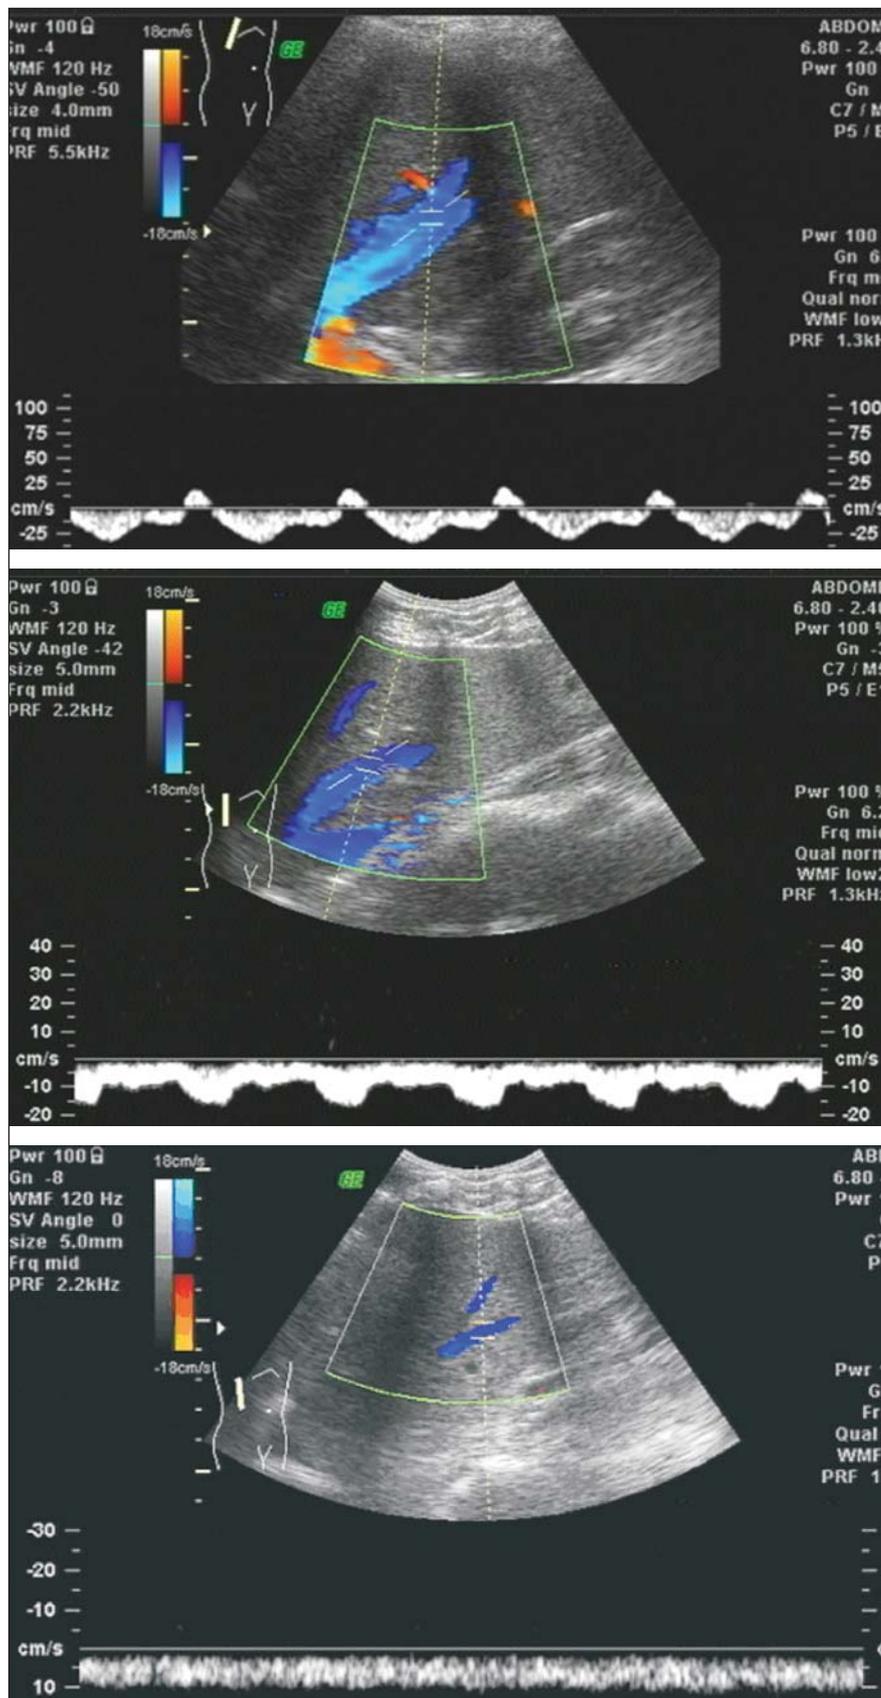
Hepatic vein flow pattern at Doppler. On the upper image, triphasic pattern; on the central image, biphasic pattern; on the lower image, monophasic pattern.
